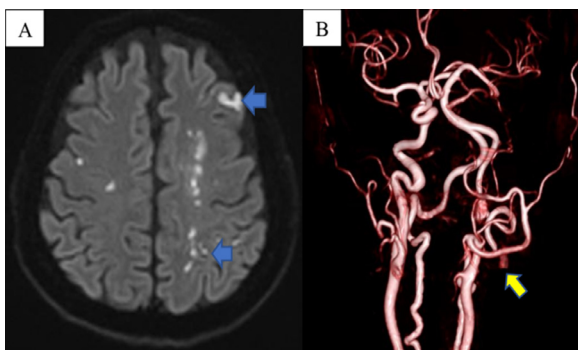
Second cerebral magnetic resonance imaging results. (A) An increase in hyperintense lesions was observed in the left hemisphere compared with the initial magnetic resonance imaging results (blue arrow). (B) Near occlusion of the ipsilateral internal carotid artery was observed (yellow arrow).
